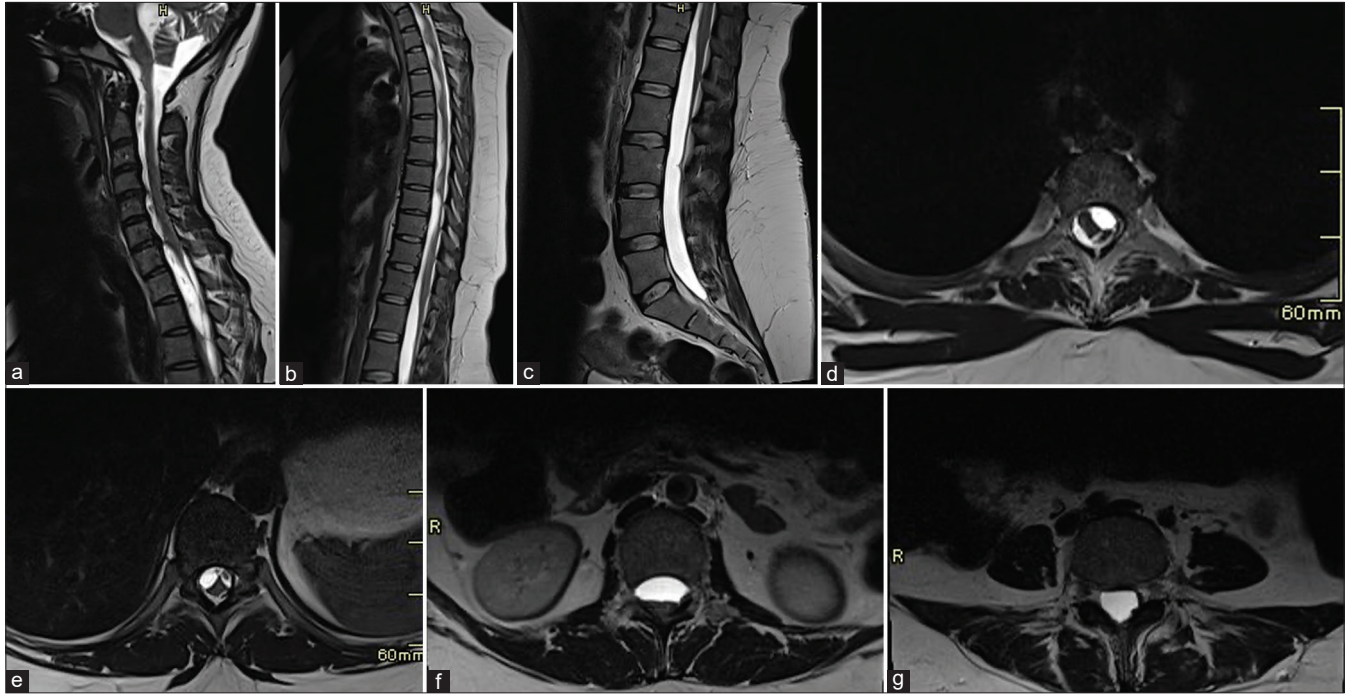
(a-g) Findings suggestive of Adhesive Arachnoiditis. Sagittal and axial magnetic resonance imaging of the spine without contrast reveals adherent cauda equina nerve roots to the thecal sac, associated with extensive intradural cerebrospinal fluid-like multiloculations extending up to the lower cervical spine encasing the thoracic cord.
